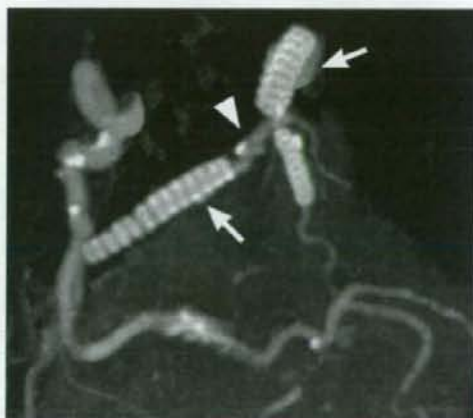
Coronary computed tomography 4 months after late stent thrombosis showed aneurysmal change in stented segments as well as incomplete stent apposition (arrows), and stenosis in non-treated segment (arrow head). Lumen diameter in LM was approximately 9 mm. Scale bar indicates 1 cm.
